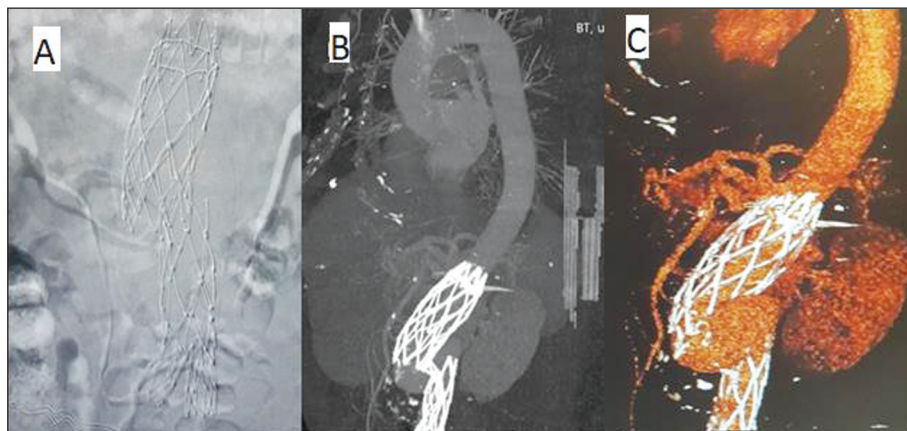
Images of Type III endoleak. The graft ends are separated as siphon-like configuration. A: Angiographic image; B, C: 3D computed tomography reconstruction images.
